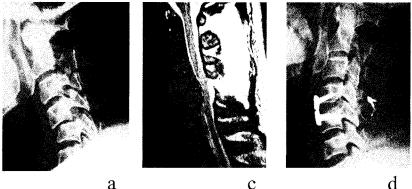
a Plain cervical lateral radiography after conservative treatment with a cervical collar for 6 months revealing progression of anterior angulation. b CT confirming unilateral interfacetal locking at C5-6. c MRI revealing cord compression due to dislocated vertebral body. d Postoperative cervical radiography demonstrating restoration of the original cervical alignment after combined arthrodesis
